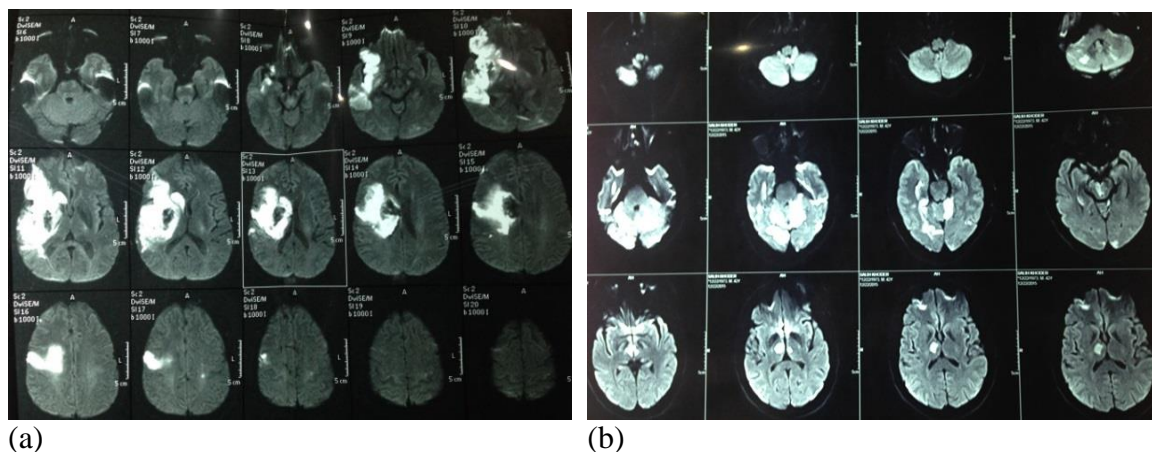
(a) Diffusion-weighted magnetic resonance image of the head of the same patient.
